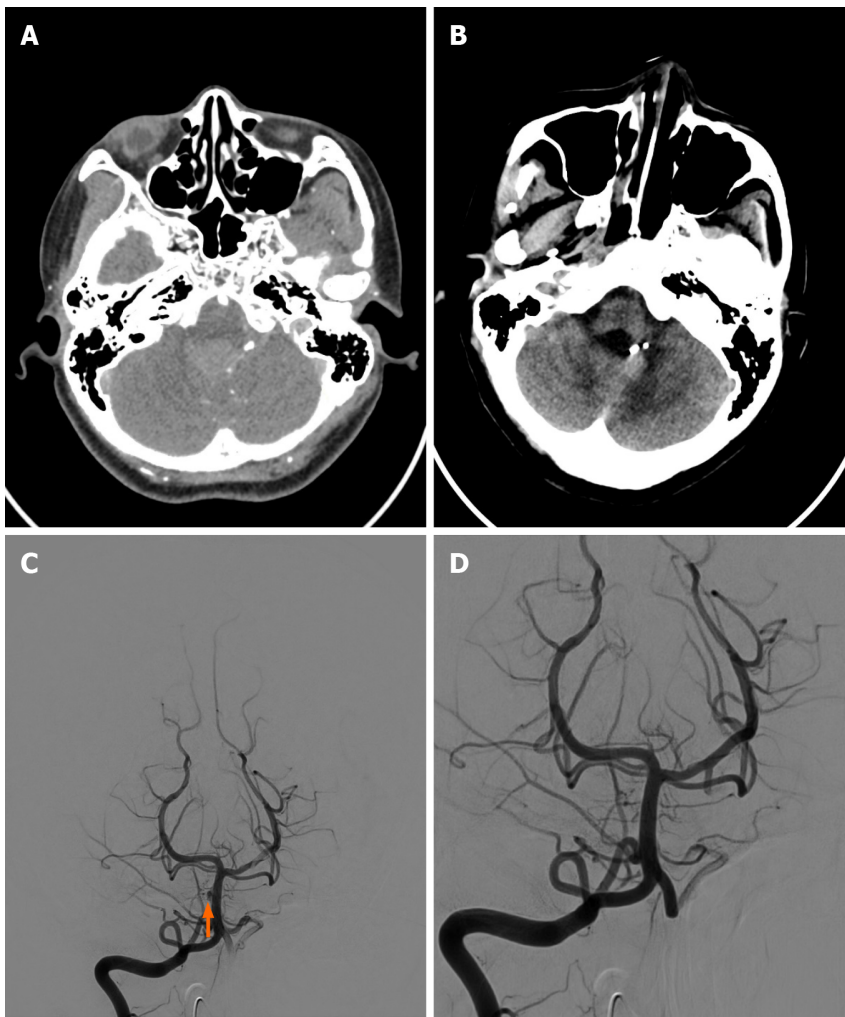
Case 3. A: Axial brain computed tomography with contrast of a 31-year-old female showed an irregular sacular structure found in one of the left distal vertebral artery meningeal branches; B: Follow-up (24 months) axial brain non-contrast computed tomography of the same patient showed the previous subarachnoid hemorrhage regressed, and no new subarachnoid hemorrhage was noted; C: Angiography showed a tiny semi-circle sacular lesion noted on the right side of the basilar artery, and it was considered an unruptured basilar artery perforator aneurysm; D: Metallic coil embolization of these aneurysms was performed.
